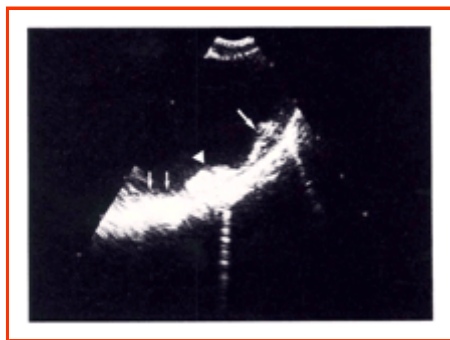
Transesophageal Echocardiogram of the Aortic Arch Obtained with a Single-Plane Probe (Transverse View).
